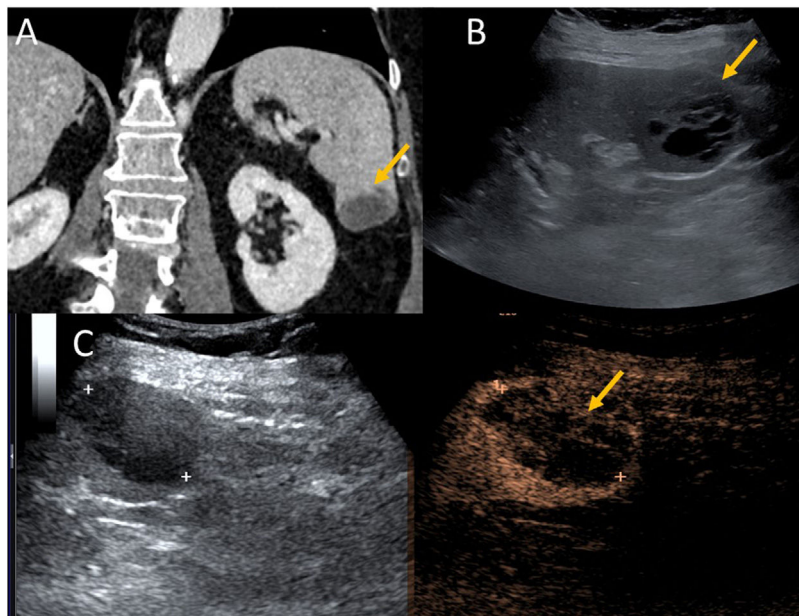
60-year-old woman attending a routine check-up. (A) Coronal computed tomography with incidental finding of a focal hypodense splenic lesion (yellow arrow). (B) Baseline ultrasound demonstrating a multilocular lobulated cystic lesion with multiple internal septa (yellow arrow). (C) Contrast-enhanced ultrasound demonstrating a cystic lesion (between cursors) with mild septal uptake (yellow arrow). The suggested diagnosis was cystic lymphangioma.
